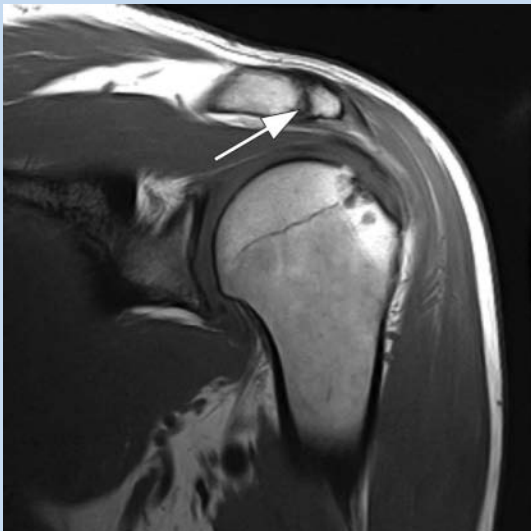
The persistent apophysis (arrow) is visible medial to the lateral aspect of the acromion on the T1-weighted coronal oblique view.
